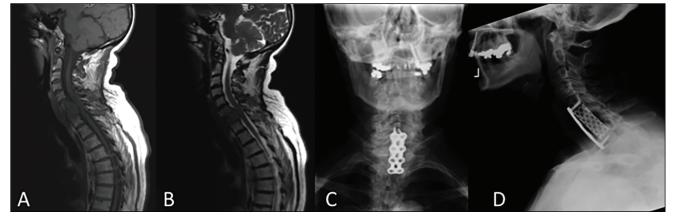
Radiologic images from Case 9, a patient with metastatic breast disease and lysis of C7: (a) T1-weighted magnetic resonance imaging (MRI); (b) T2-weighted MRI; (c and d) plain radiographs of reconstruction
